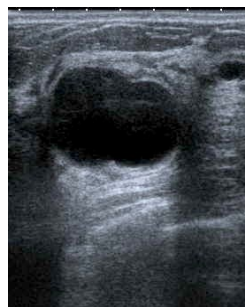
A typical Ultrasound image
